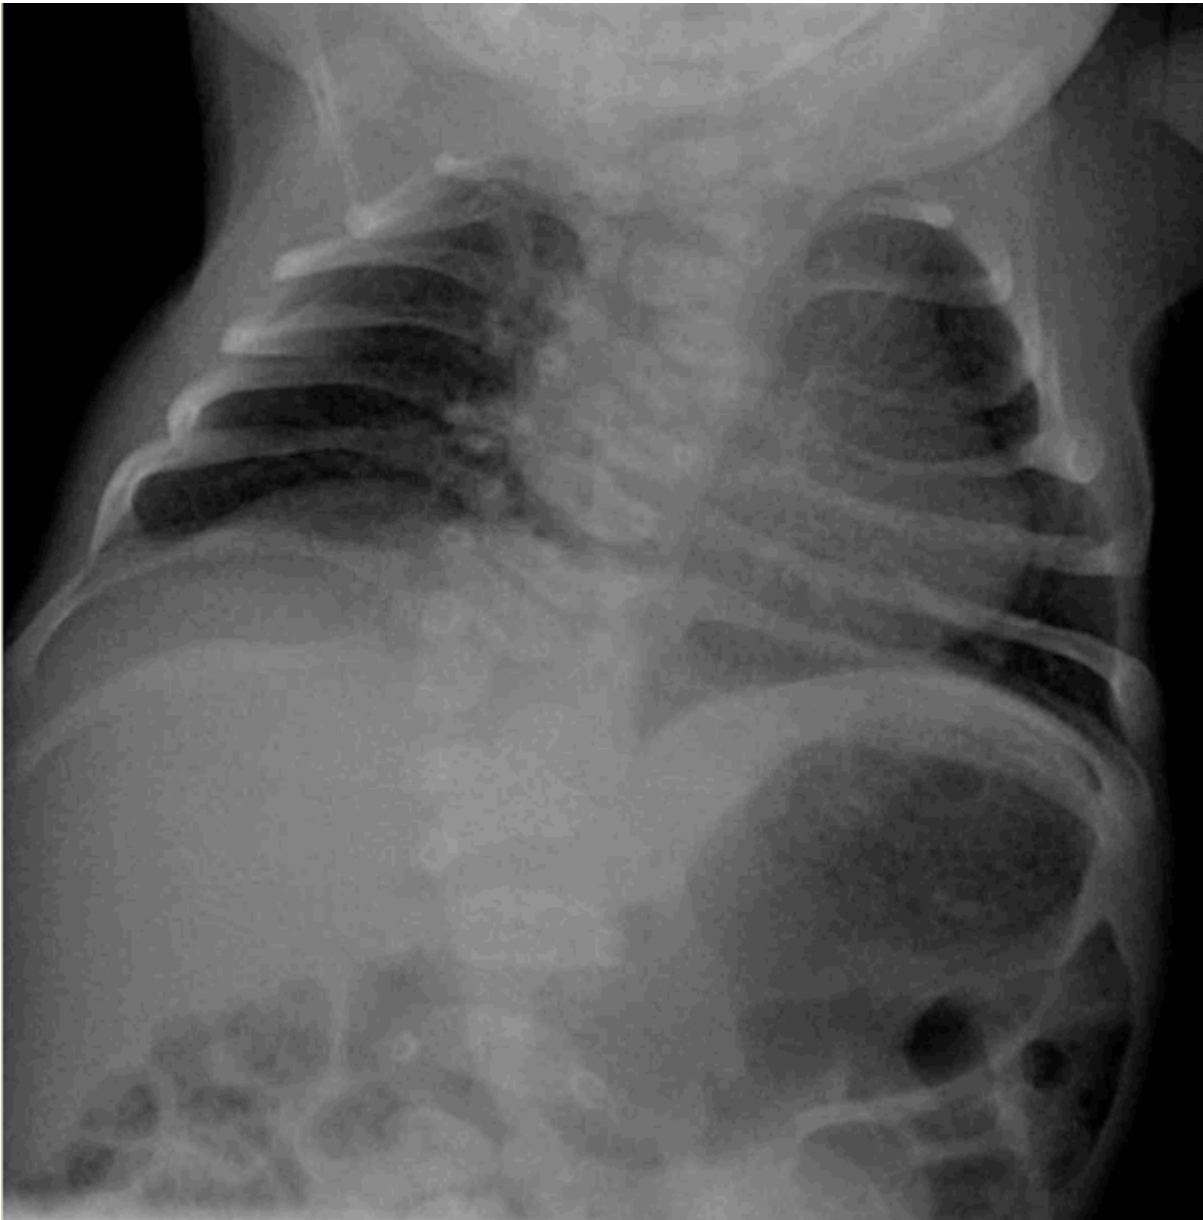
Radiograph of infant with *DLL3*-related SCDO and unusually severe scoliosis
